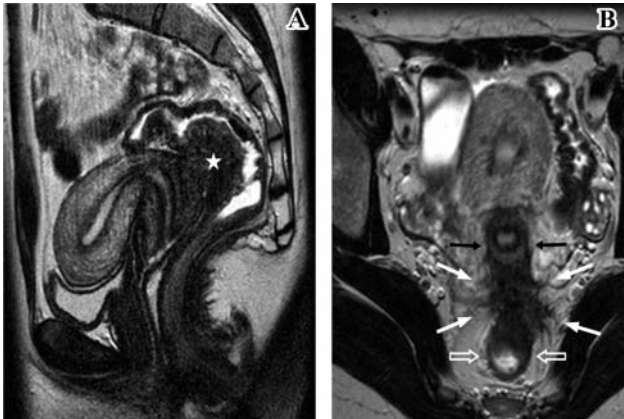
MRI of the pelvis. Sagittal T2W image (A) reveals a low-signal intensity mass (asterisk) of the cul-de-sac. On the axial T2W image (B) the plaque (white arrows) is seen extending from the posterior aspect of the cervix (black arrows) to the anterior wall of the rectosigmoid (open arrows). Low-signal spicules are seen radiating from the mass towards the adjacent fat.
